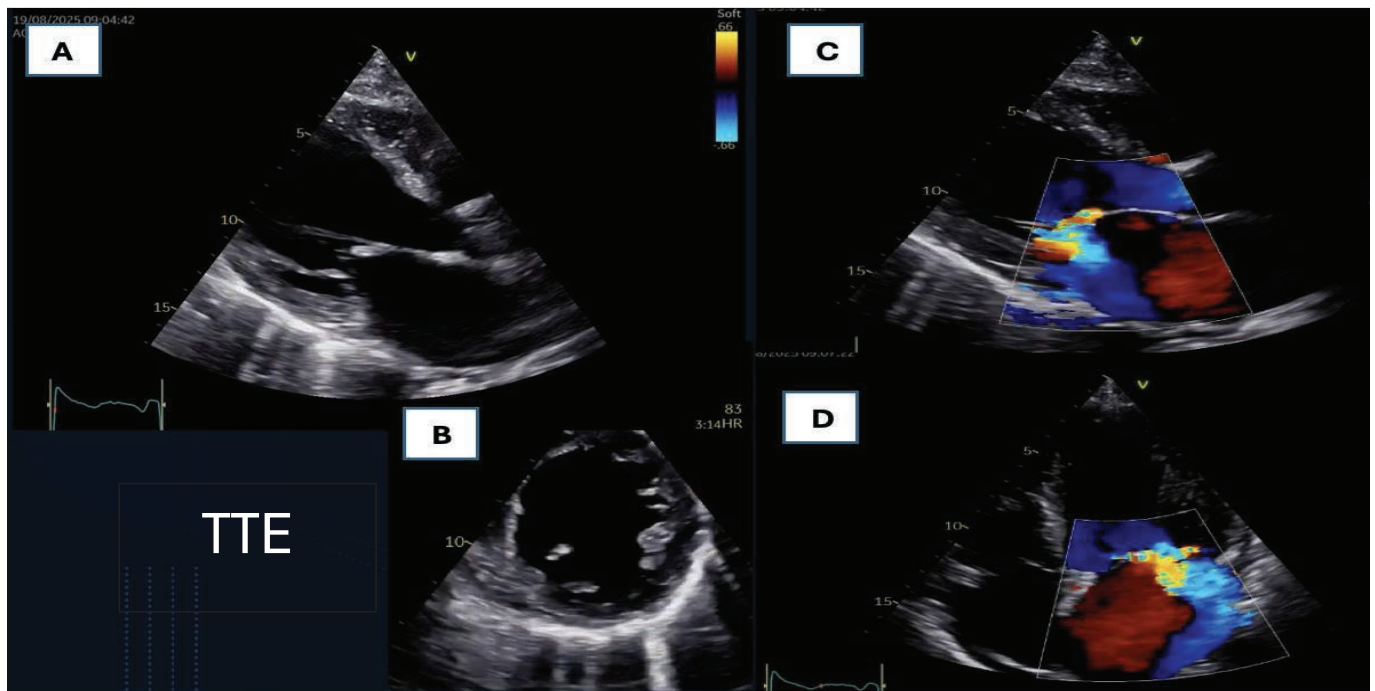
TTE demonstrates a severely dilated left ventricle in the parasternal long-axis (PLAX) (A) and short-axis (B) views. Color Doppler imaging reveals an eccentric, posteriorly directed mitral regurgitation jet in the PLAX (C) and apical four-chamber (D) views, consistent with FMR in the setting of LV dilatation and leaflet tethering.
